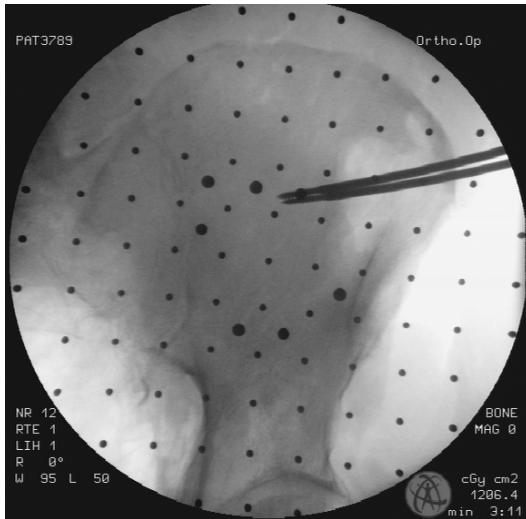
First X-ray image during registration
